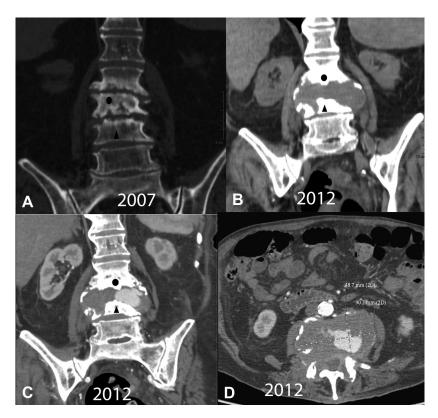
A, Nonenhanced computed tomography (CT) scan, coronal view: bifocal spondylodiscitis L2-L3 and L3-L4 showing loss of disc height and vertebral endplates erosion. B, Nonenhanced CT scan, coronal view: hypodense mass lesion located inside the destructed L3 and L4 bodies. C and D, Enhanced CT scan coronal and plain views revealing a voluminous pseudoaneurysm with thrombus inside. *Circle* = L3; *triangle* = L4.
